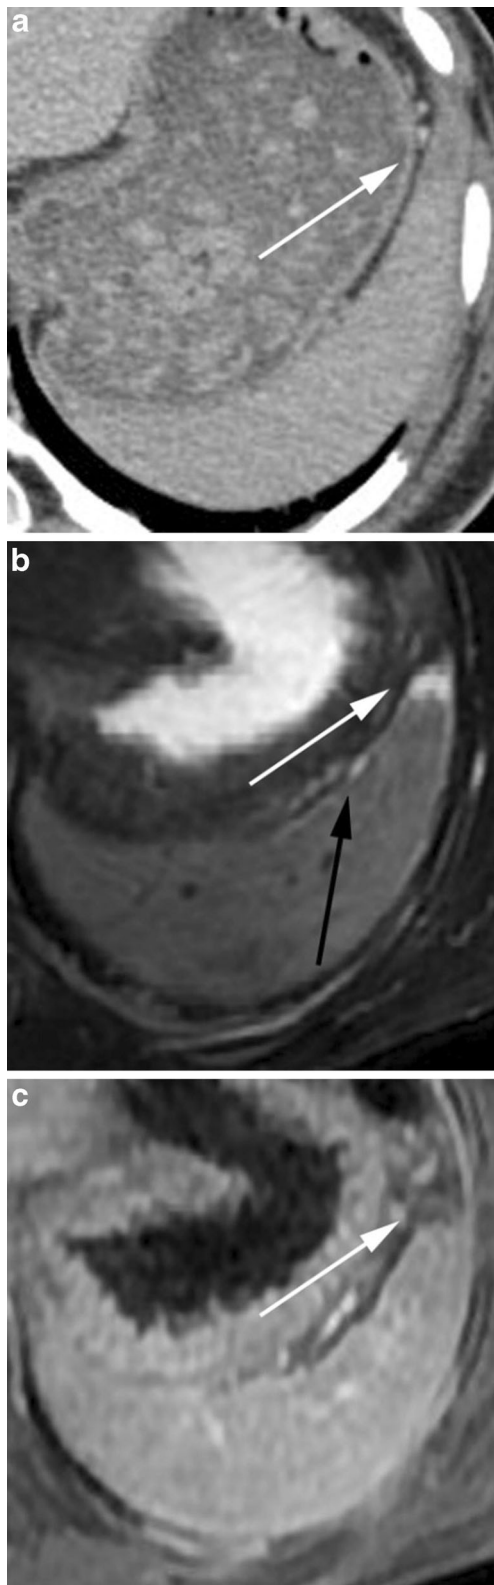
A 25-year-old woman with blunt abdominal trauma after motor vehicle accident. a Transverse portal-venous phase CT shows a mild hypodensity at the ventral pole of the spleen (*white arrow*). b T2-weighted MR images at the same level demonstrate an ill-defined hyperintense lesion (*white arrow*) with a thin subcapsular hematoma (*black arrow*). c Contrast-enhanced T1-weighted MR images in the venous phase show a small hypointense lesion (*white arrow*), indicating hyperacute intra-parenchymal hemorrhage
